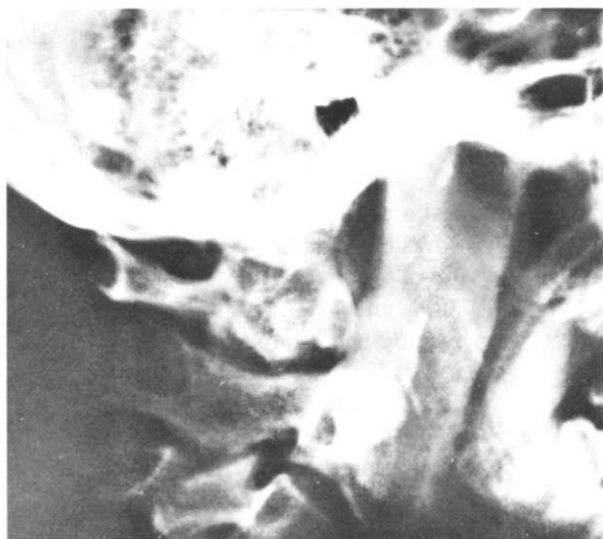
Radiographs of a 34-year-old man involved in a motorcycle accident. (Top) The patient sustained a posterior dislocation of the atlas on the axis. The patient had a 4 × 4-cm abrasion over the left parietal region. (Bottom) The fracture was reduced by manual traction and manipulation applied through Vinke tongs without anesthesia. Note the small splinter of bone at the anterior base of the dens that can be seen in both the pre- and postreduction films. The MIV is shown in the inset and is primarily a vector orientated in the y, z plane, making approximately a 30° angle with the positive y-axis. In order to force the anterior ring of C1 up to the tip of the dens and then posterior to it, a posteriorly directed extension injury must have occurred. (Radiographs from Patzakis, M. J., Knopf, A., Elfering, M., et al.: *Posterior dislocation of the atlas on the axis: a case report*. *J. Bone Joint Surg.*, 56A:1260, 1974.)
